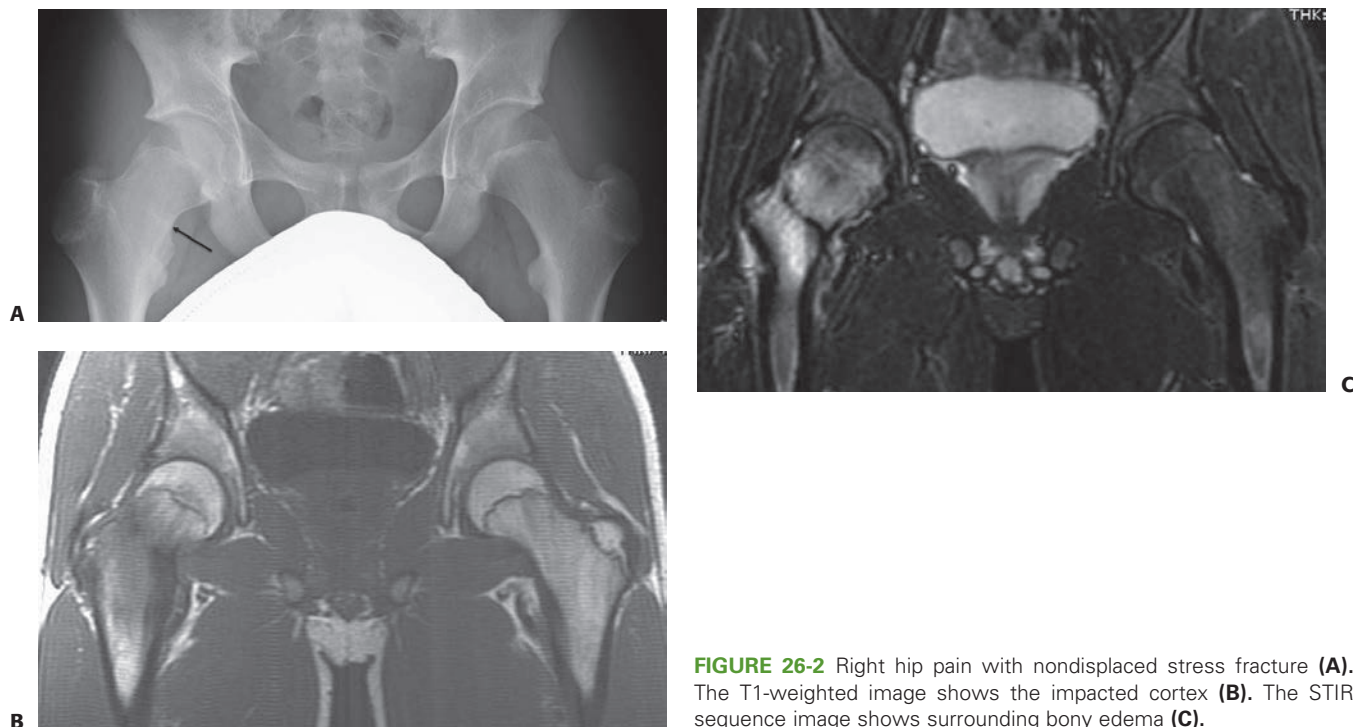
Right hip pain with nondisplaced stress fracture (A). The T1-weighted image shows the impacted cortex (B). The STIR sequence image shows surrounding bony edema (C).
